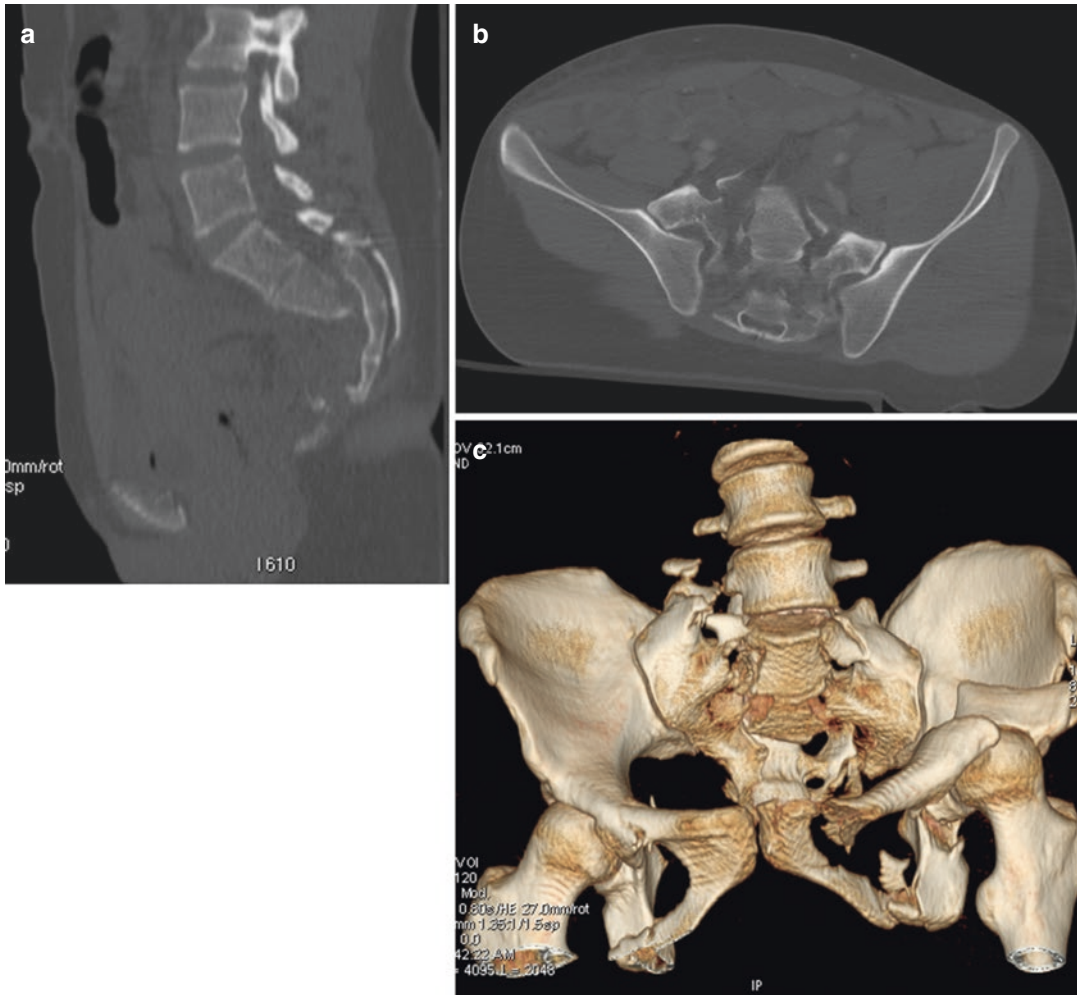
Unenhanced CT scan; sagittal (a), axial (b) images, and 3D volume rendering (c). A complex fracture of the sacrum and ileus involving the ischiatic foramen
